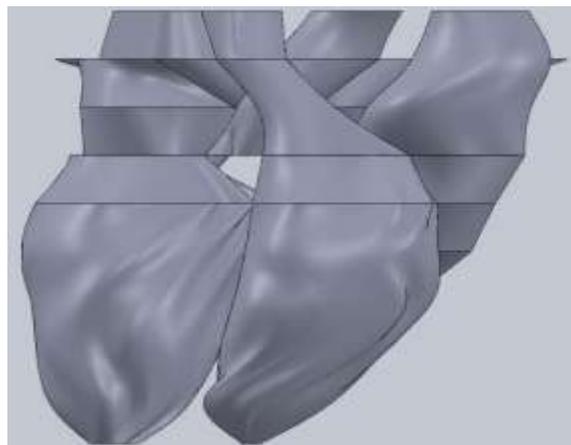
MRI Approximation – Construction Planes – Front View
